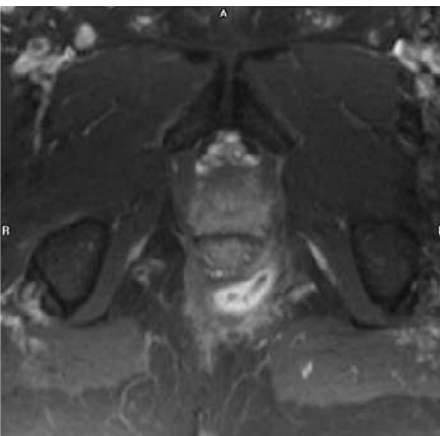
Axial T2-weighted image with fat saturation. Grade 4 perianal fistula with an ischioanal fossa abscess
